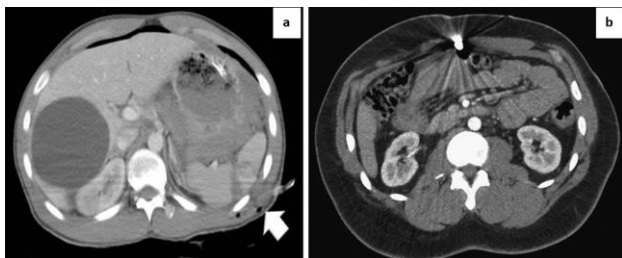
a) Left flank stab injury: axial CT demonstrates wound path analysis with splenic laceration and hemoperitoneum. b) Bullet injury anterior abdomen: axial CT line of possible injuries.
